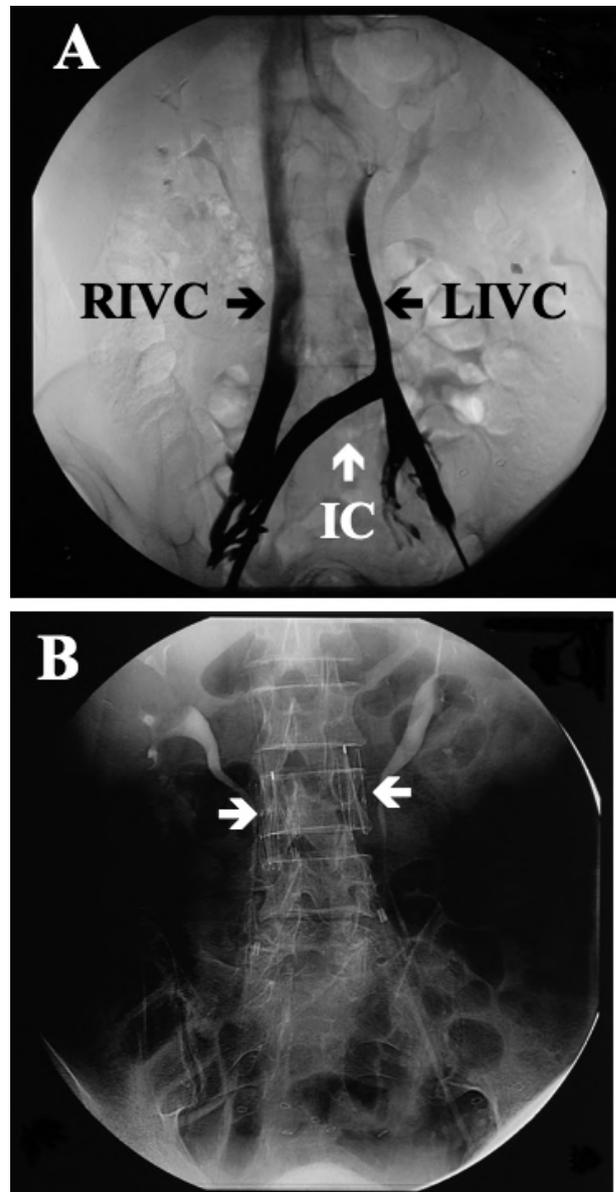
Congenital double inferior vena cava and dual filter placement. (A): Venography showing the congenital double inferior vena cava (IVC) with an infrarenal interiliac communication (RIVC= right IVC; LIVC = left IVC; IC = interiliac communication). (B): Direct abdominal X-ray showing two VenaTech filters placed in the duplicated IVC (arrows).
